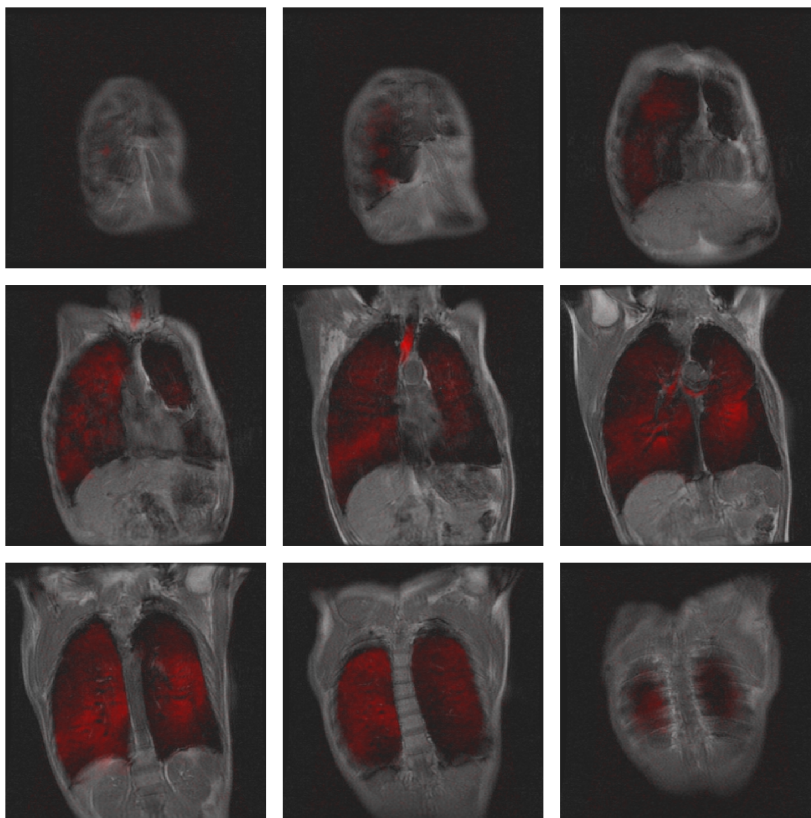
Coronal co-registered HP ¹²⁹Xe-MR ventilation imaging and proton MRI acquired from OXF0139. Co-registration to proton MRI enables the lung boundaries to be defined.
